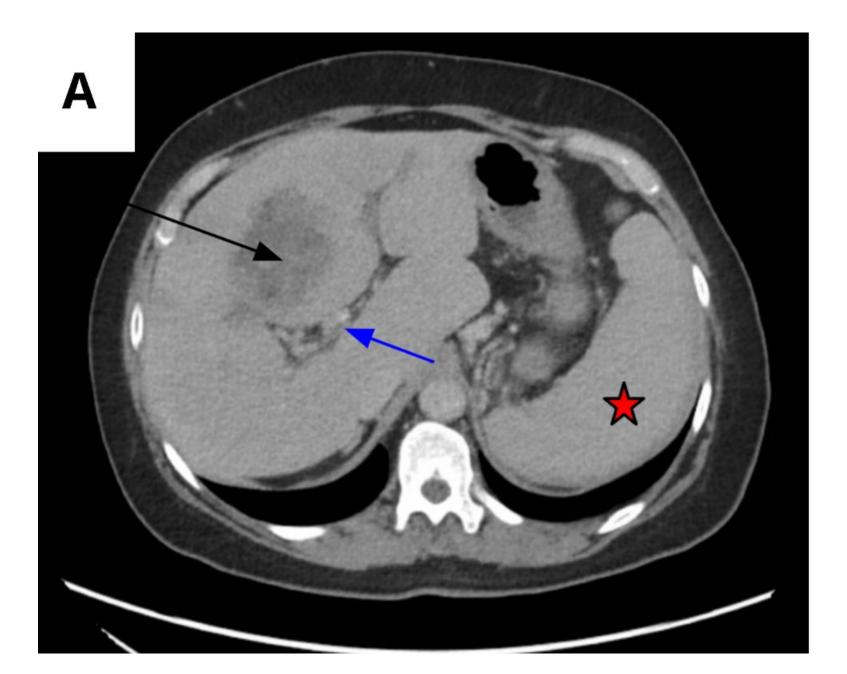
Heterogeneous cystic liver mass in the segment IV of the liver measuring 6.2 x 5.8 cm on Computed Tomography (Image A, see black arrow), and Magnetic Resonance Imaging with enhancing internal septa, and enhancing walls (Image B, see black arrow). Additional findings of portal hypertension included a cavernous transformation of the portal vein (see blue arrows), splenomegaly (see red stars) and splenorenal shunt.
